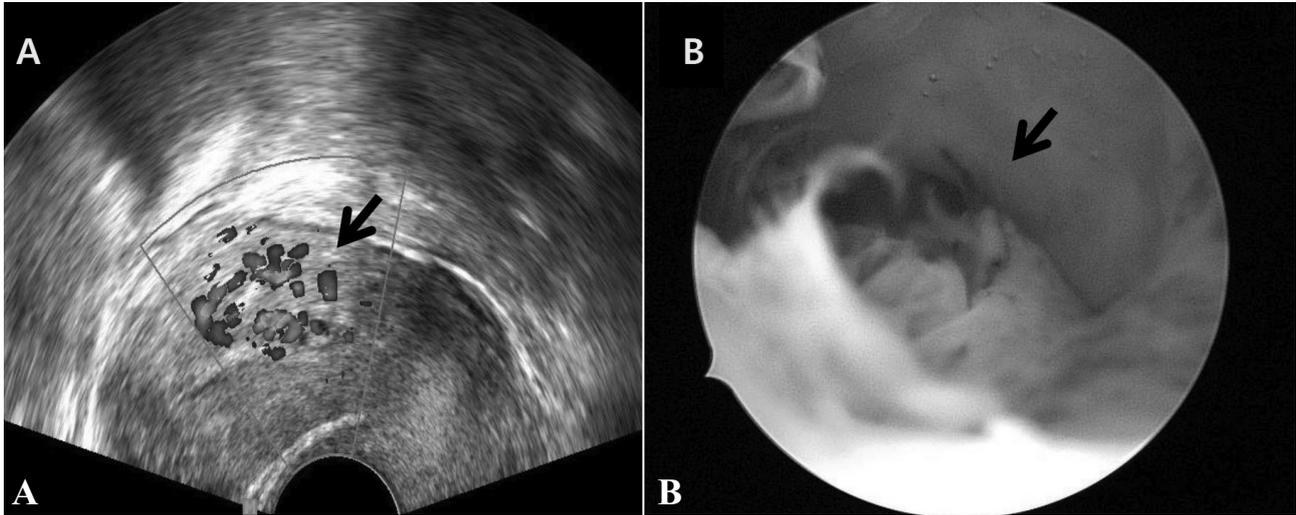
Diagnostic images of gestational trophoblastic neoplasia. The black arrow indicates isolated mass on posterior uterine body. The diameter of the mass is 2.3 cm. A) Transvaginal Doppler ultrasonogram of isolated lesion with high vascularity invading uterine wall. B) Hysteroscopic image of mass-like lesion of uterus.
